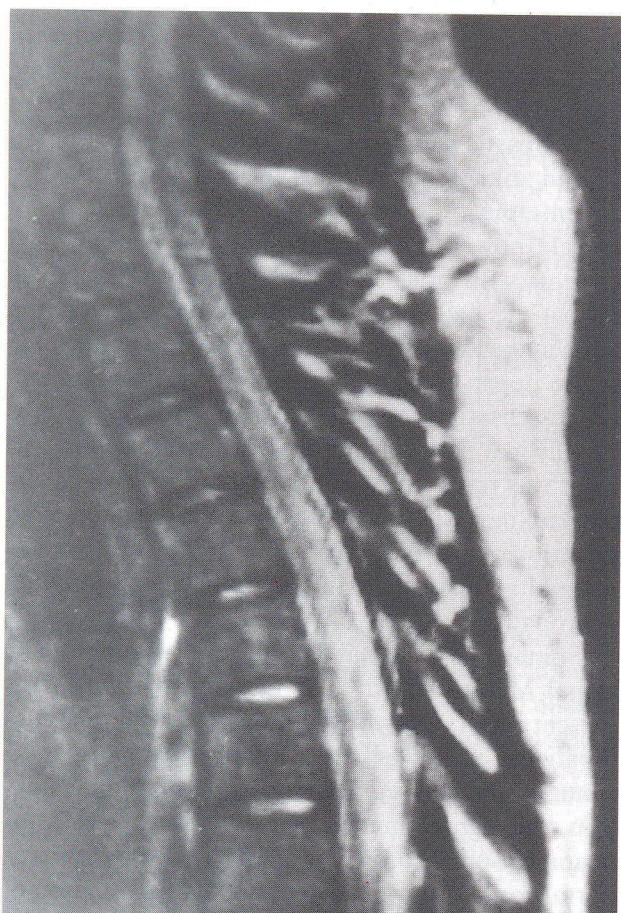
Spinal MRI, T2 sequence of a patient with subacute combined degeneration showing hyperintense signal changes in cervicodorsal region in sagittal section (a) which is located mostly in the posterior part of the spinal cord (axial section b).
